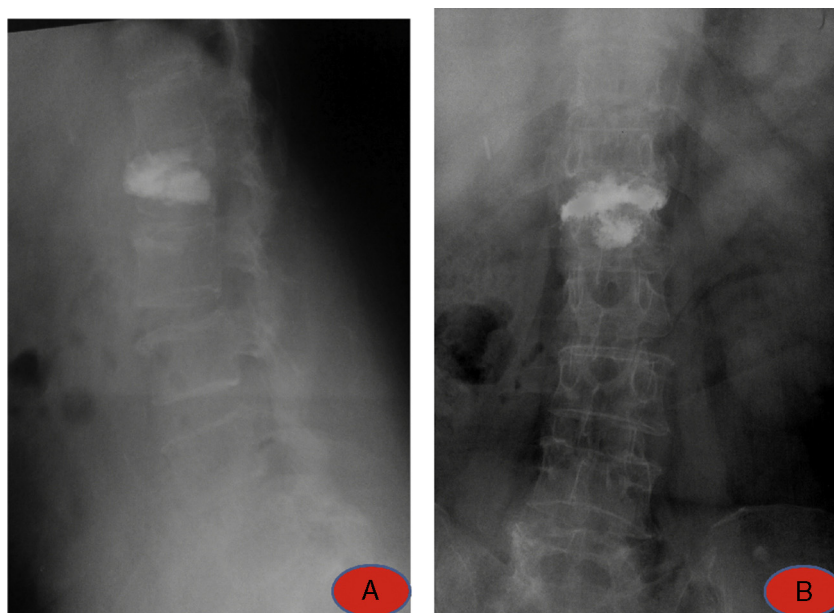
(A) Postoperative X-ray (AP). (B) Postoperative X-ray (lateral).
